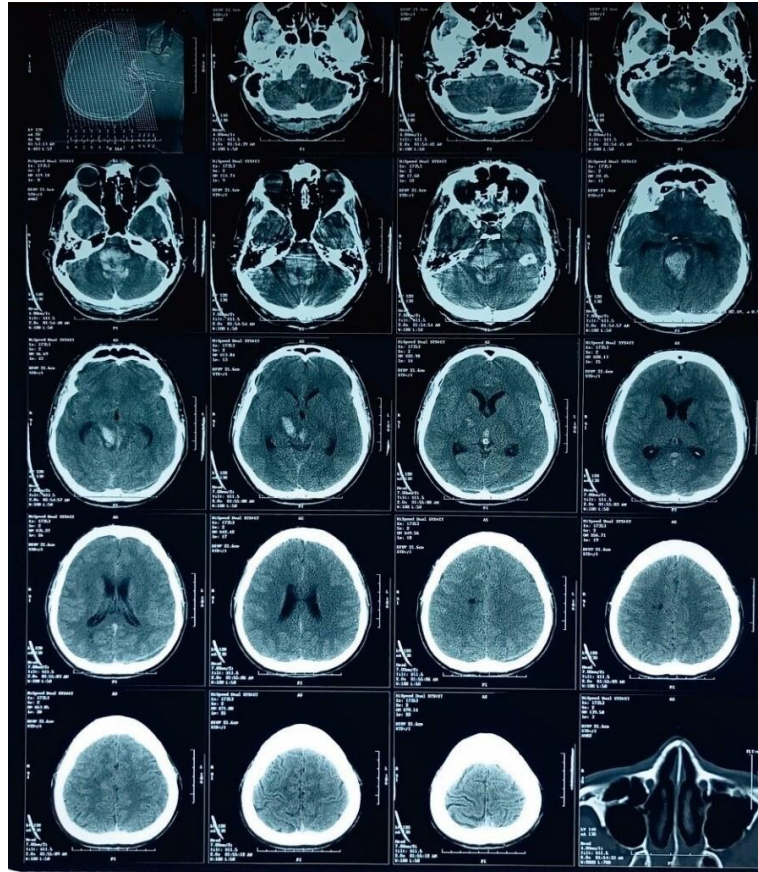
Head CT scan without contrast showed intracerebral and intraventricular hemorrhage with the estimated total hemorrhage volume of about 31 ml
